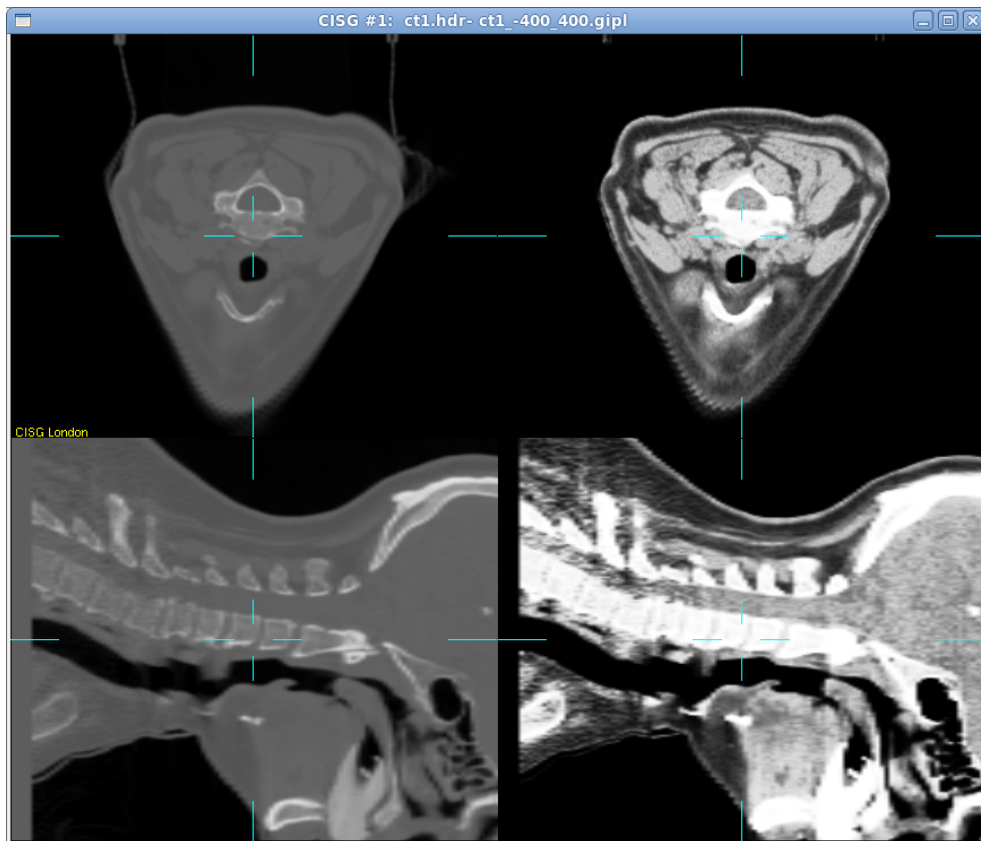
CT image before (left) and after histogram equalisation (right)
